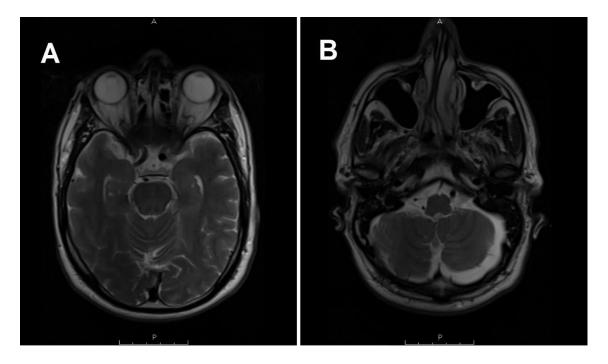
Normal axial proton density (PD)+T2-weighted turbo spin echo (TSE) MRI images of the patient.
